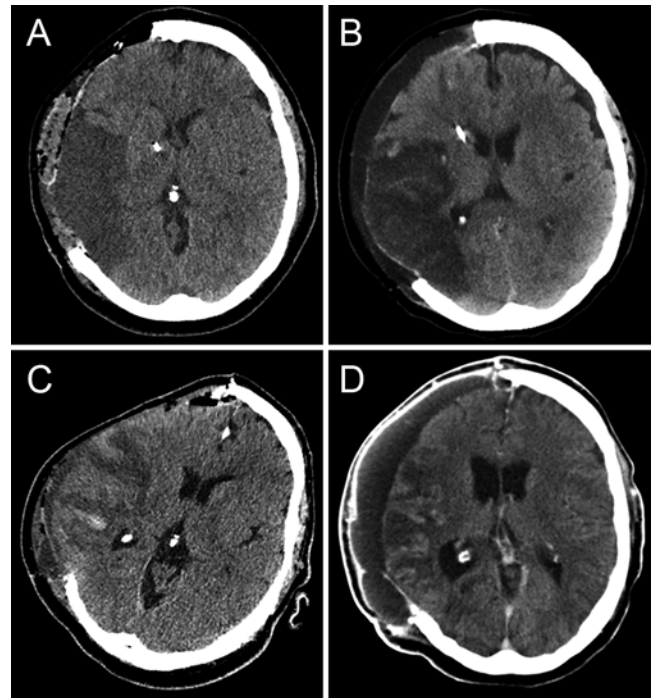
Subdural hygroma and subgaleal CSF accumulation. A and B: CT scans obtained on the 1st (A) and 5th (B) postoperative days, showing subgaleal CSF accumulation in a 60-year-old female patient with MHS without lumbar drainage who had to undergo surgical wound revision. C and D: CT scans obtained on the 1st (C) and 17th (D) postoperative days, showing progressive hygroma in a 54-year-old male patient with MHS who underwent lumbar drainage and had to undergo revision with evacuation of the hygroma because of mass effect.
